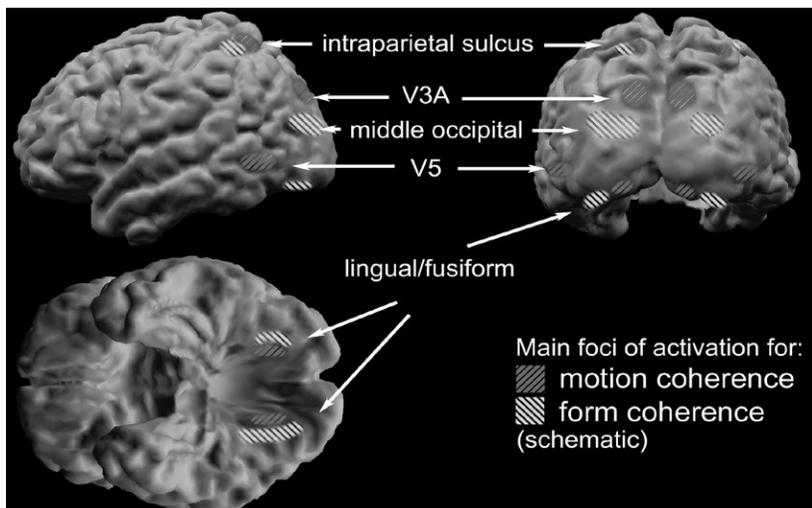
Areas of the brain associated with form and motion processing, identified with MRI (*Ageing vision, Part 3: Visual dysfunction in Alzheimer's disease. Optometry Today 11/2/11 p 37-40, Used with Permission of Justin O'Brien, Brunel University and Optometry Today*)
